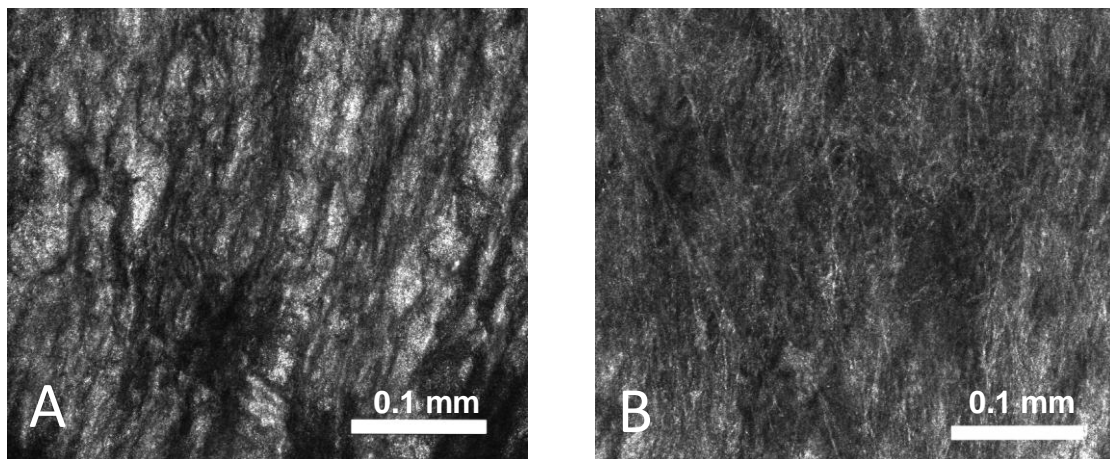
Reflectance images of different layers of EC. A – image of the most superficial – endothelial layer; B – image of the deeper – CT layer at 16 μm depth.
